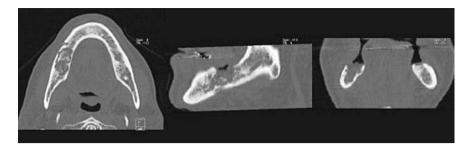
and 10. SPECT-CT Imaging 3,5 hours after Injection of ^{99m}Tc-DPD.
